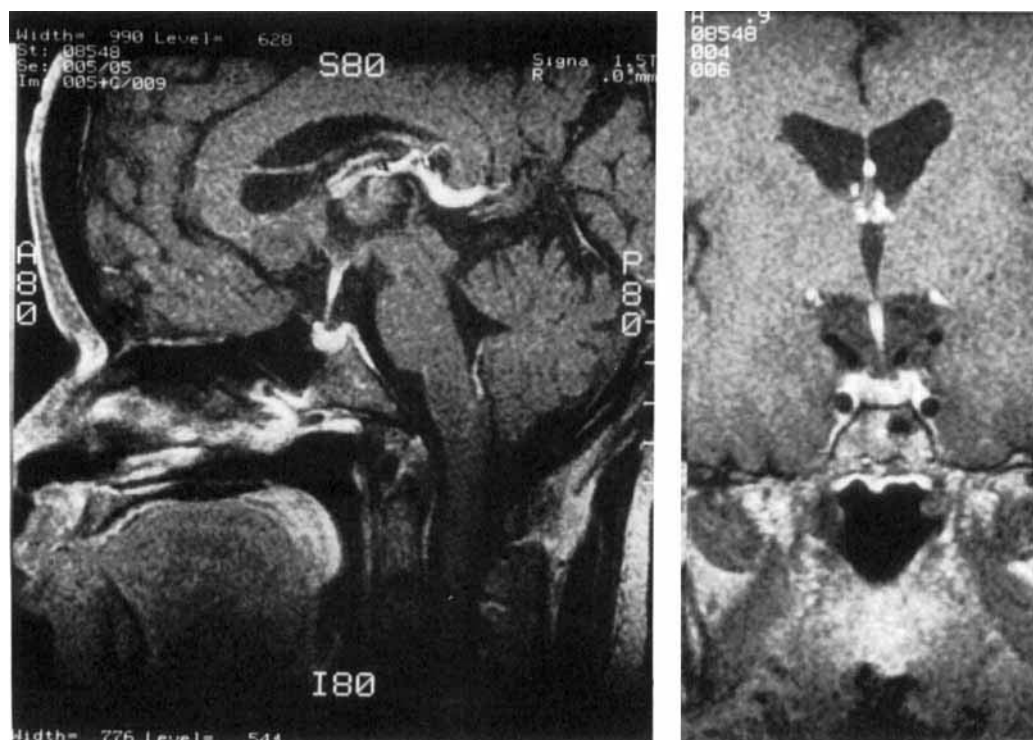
Gd-DTPA enhanced MRI of sagittal section (left) and T₁ enhanced MRI of frontal section (right) of the pituitary gland. Pituitary stalk is prolonged and suprasellar cistern is wide. Optic nerve is not visible. The upper part of pituitary gland is enhanced by Gd-DTPA.
